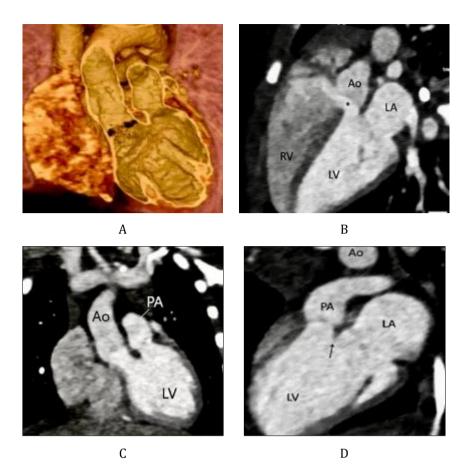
(A) Cardiac CT: Multiplanar 3D reconstruction of CT angiography. The hollow parts are the LV Chamber, with Ao on the right and PA on the left. (B) Multiplanar reformatted CT angiography in a long axis orientation of the LV. The Ao overrides the VSD (denoted by asterisk) with a left to right shunt. (C) CT Angiography: Oblique view shows the Ao and PA in side-by-side orientation, originating from LV. More than 50 % of the Ao is seen arising from the LV. (D) CT angiography: In the long axis view, the PA arises entirely from the LV, with no pulmonary-mitral fibrous continuity due to the presence of a part of subarterial conus (arrow)
